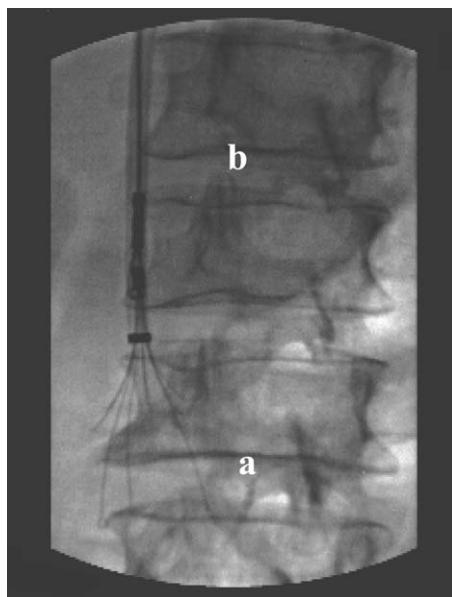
X-ray image of the implantation of an ALN filter. Note (a) the filter and (b) the catheter that released it in the vena cava.
